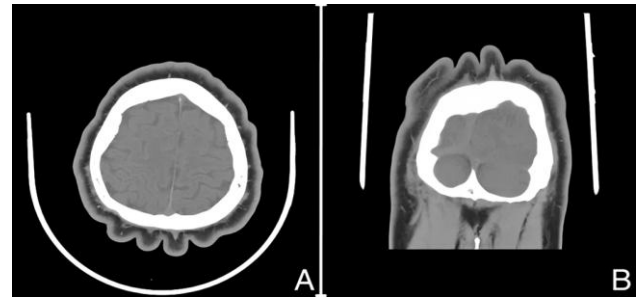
CT scan axial (A) and coronal (B) views showing thickening of the scalp with ridges and furrows involving the dermis and subcutis in the parietal and occipital regions (Reprinted with permission of patient)
